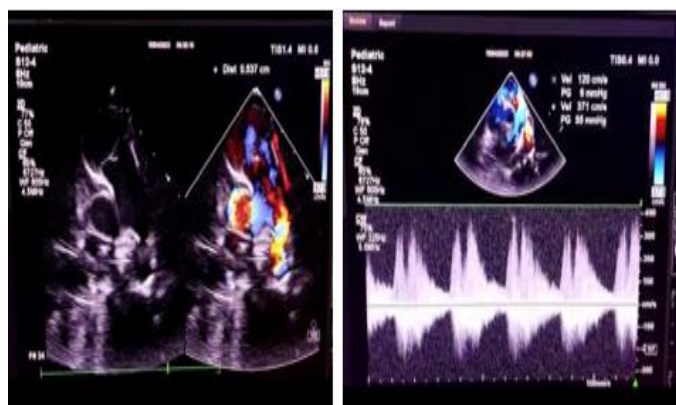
The Transthoracic Echocardiography (TTE) Examination Has Confirmed The Presence of A 5 Mm PDA. Continuous Wave (CW) Doppler on The PDA Indicates A Continuous Flow Pattern with A Systolic Gradient of 55 Mmhg and Diastolic Gradient of 6 Mmhg.
